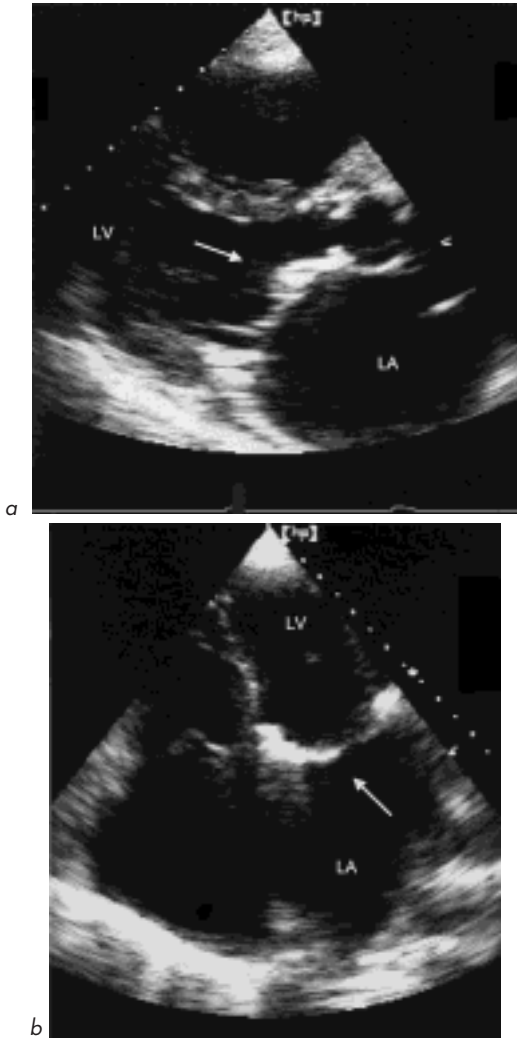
Calcification of mitral annulus (arrow). This was asymptomatic, with no mitral stenosis or regurgitation. (a) Parasternal long-axis view, (b) Apical 4-chamber view.
